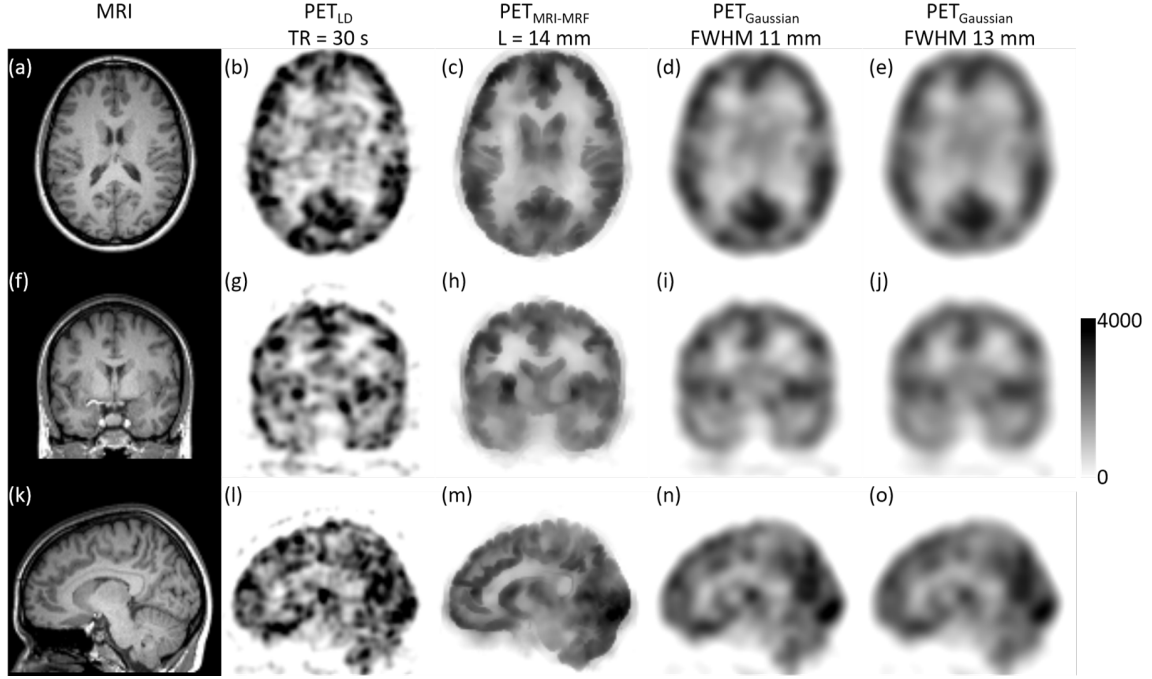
Comparison of denoised *in vivo* images using different methods. Assessment of the post-reconstruction smoothed fPET images with binning time of  $T_{bin} = 30$  s. The subject's MRI image (a); the vendor reconstructed PET image (b); the filtered image using the MRI-MRF prior ( $L = 14$  mm) (c); and using Gaussian kernels with FWHM (d) 11 mm, (e) 13 mm.
